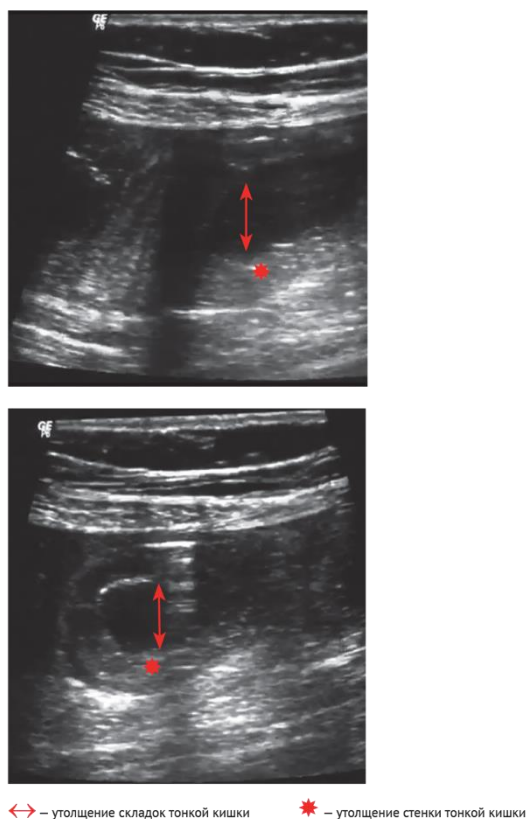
Ultrasonogram of the abdominal cavity of patient G. — signs of small bowel obstruction
